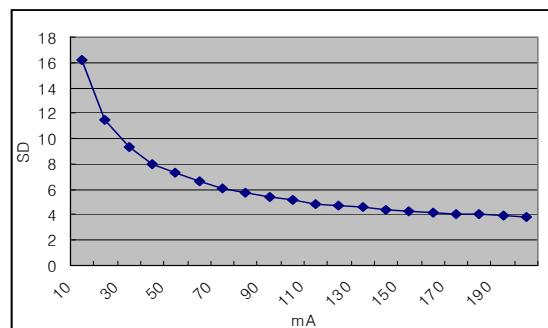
Graph of CT Images' SDs
